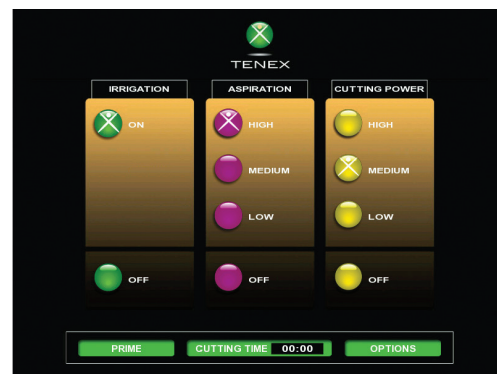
The TX Console is typically placed in the high setting for aspiration and on medium setting for the ultrasonic energy cutting function for both soft and osseous tissue.
